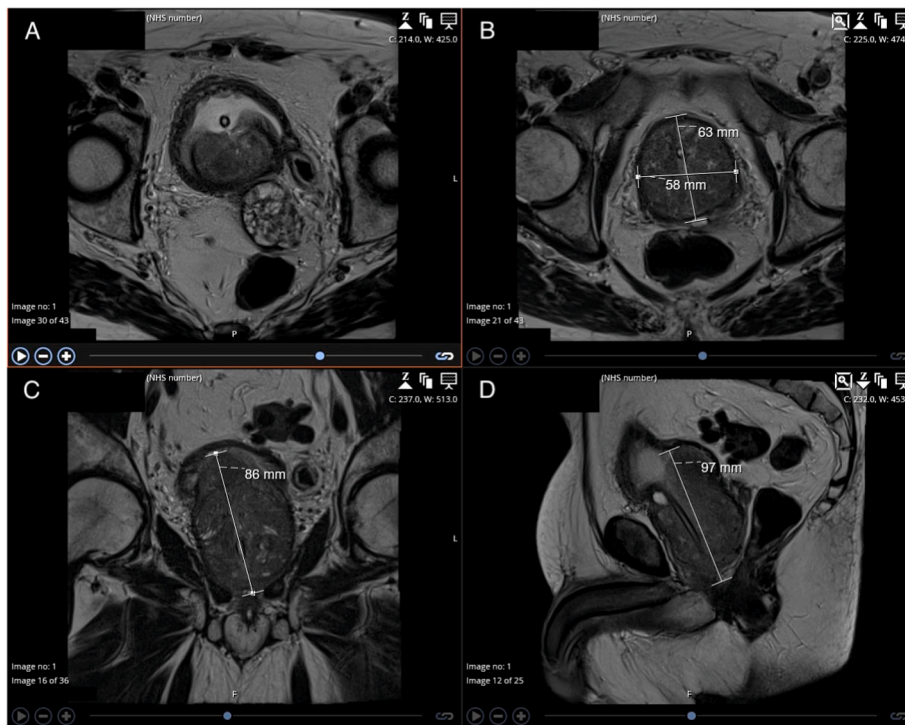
Magnetic resonance imaging (MRI) images of the prostate: (A) axial section showing the median lobe of the prostate and catheter in situ, (B) axial section showing prostate dimensions, (C) coronal section, and (D) sagittal section.
